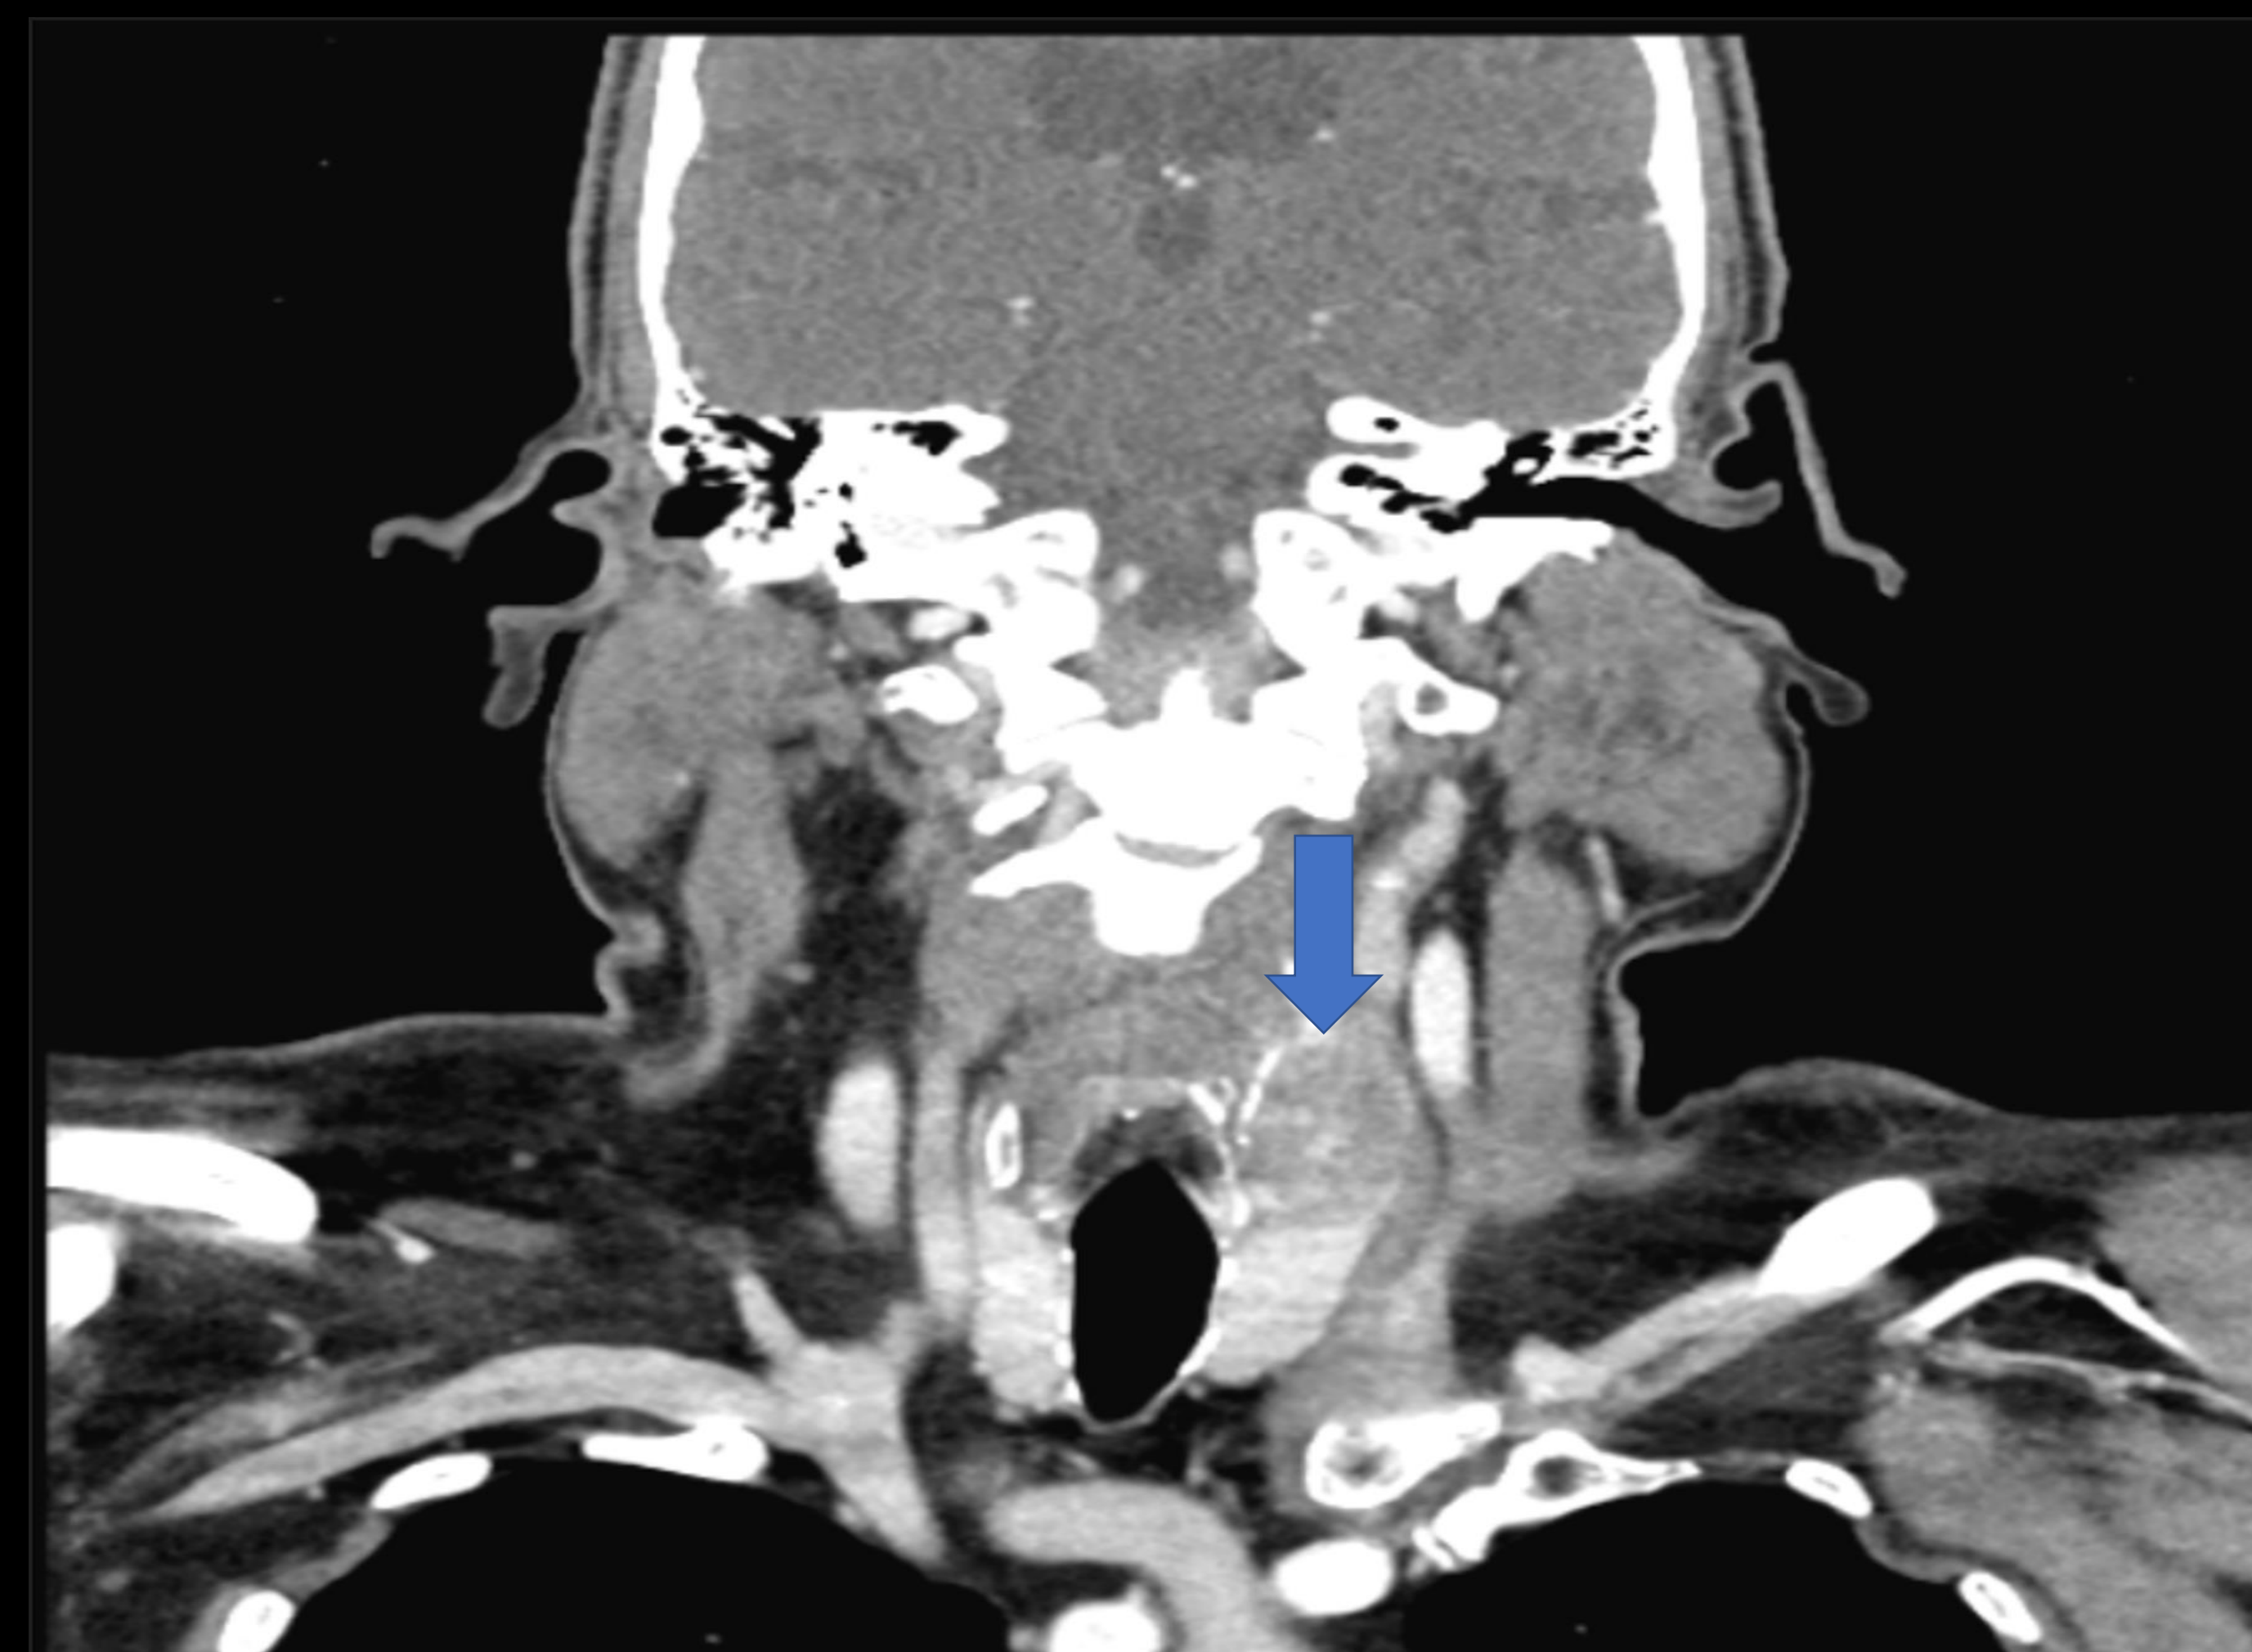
Coronal image of contrast-enhanced neck CT soft tissues partially showing a large complex hyper vascular mass (blue arrow) in the left aspect of the neck involving the superior pole of the left thyroid lobe.
